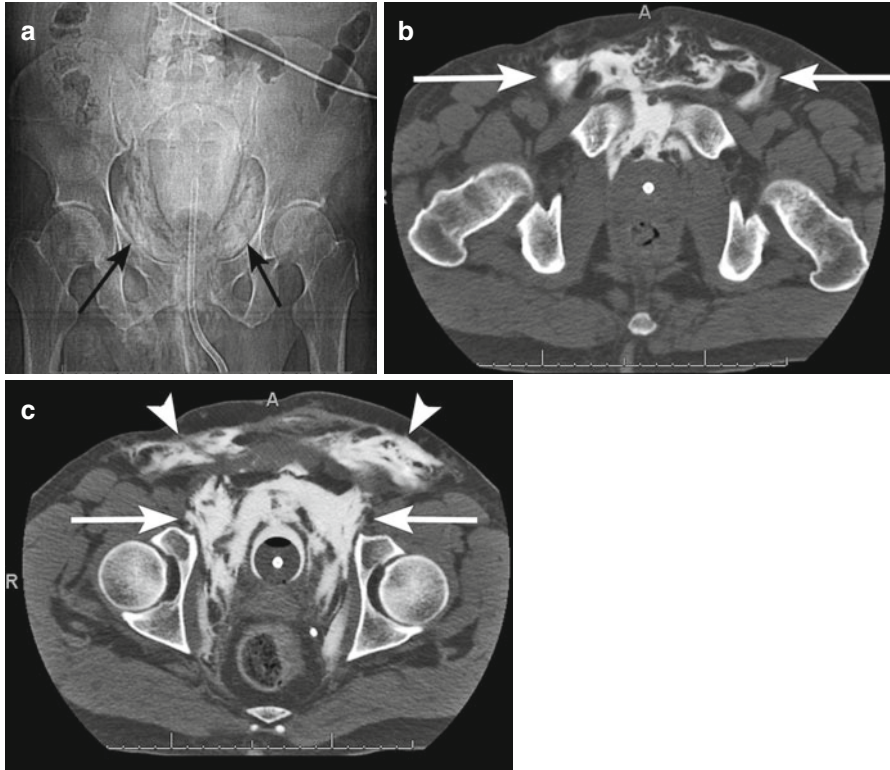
A 51 year-old male presents after motor vehicle collision. (a) Pelvic radiograph after infusion of contrast into the urinary bladder shows extravasation of contrast (*arrows*) into the perivesicular tissues, consistent with extra-peritoneal bladder rupture. (b) Image obtained during computed tomography (CT) cystoscopy shows contrast material (*arrows*) extravasated into the perivesical tissues, consistent with bladder rupture into the extraperitoneal space of the pelvis. (c) More inferiorly, the extravasated contrast material dissects through the extraperitoneal space of the pelvis in the “molar tooth” configuration (*arrows*), characteristic of extraperitoneal bladder rupture. Contrast also extends along the anterior pelvic wall (*arrowheads*)
